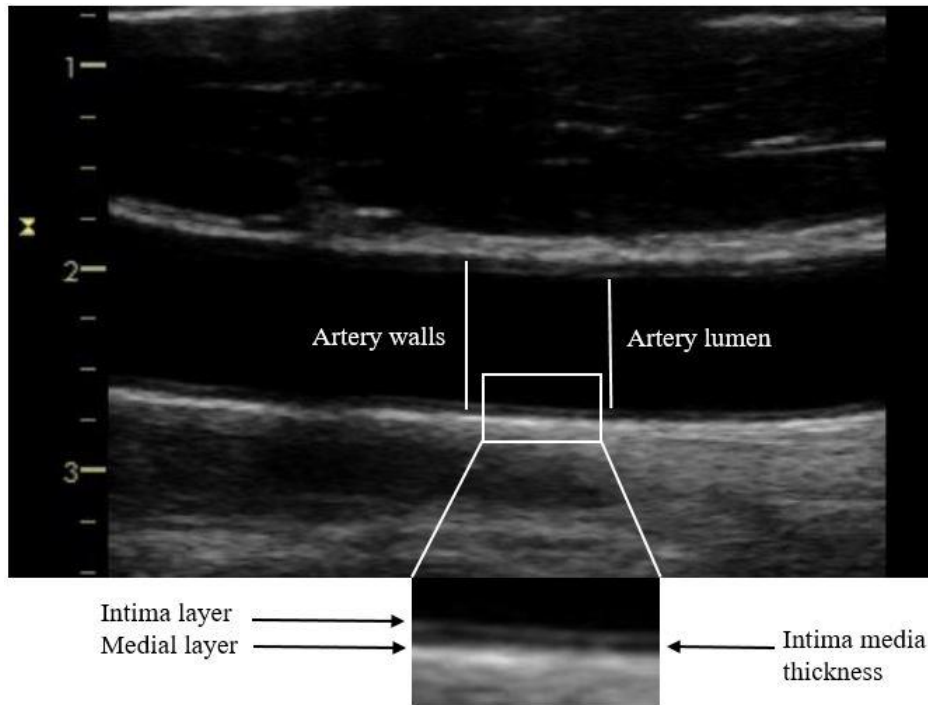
Ultrasound image of the CCA demonstrating arterial landmarks used for distensibility and intima-media thickness calculations.*
